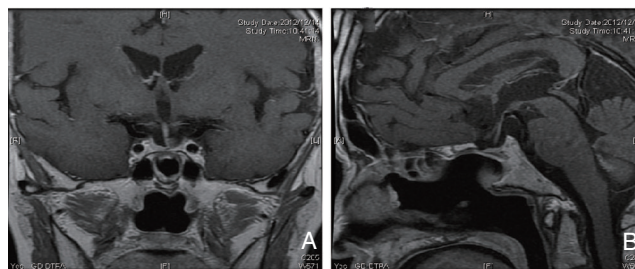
Postoperative follow-up MRI. A coronal section (A) and a sagittal section (B) of the 3-year postoperative MRI, showing no recurrence of the intrasellar mass. MRI: magnetic resonance imaging.
